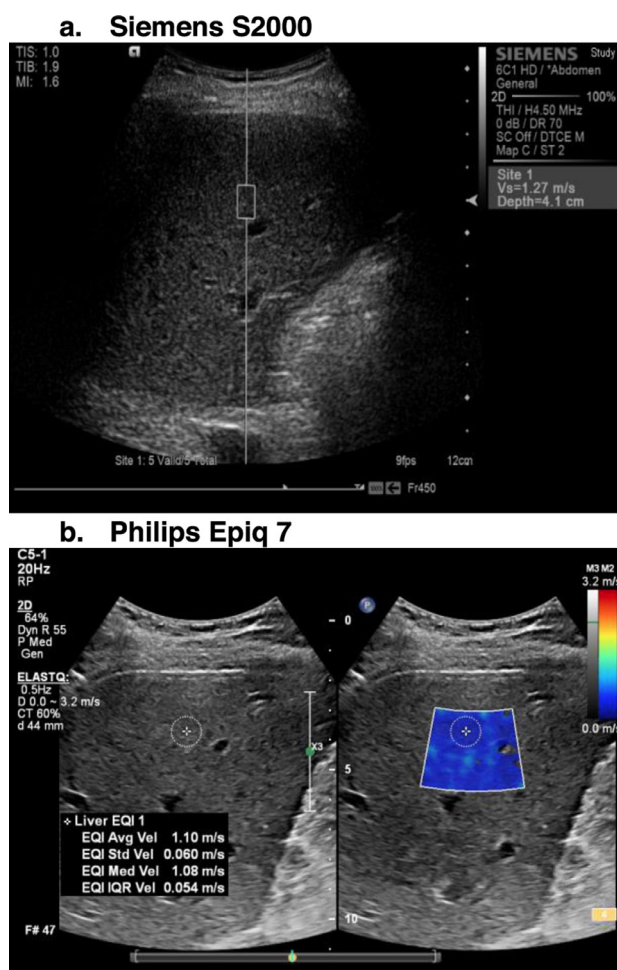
Ultrasound elastography images of the liver in segment 8 (transverse plane) obtained in the two different groups. (a) Point shear wave elastography (pSWE) on a Siemens scanner in group 1 (51-y-old female patient with abnormal liver function studies). (b) Two-dimensional shear wave elastography (2-DSWE) on a Philips scanner in group 2 (42-y-old male patient with chronic hepatitis B).
